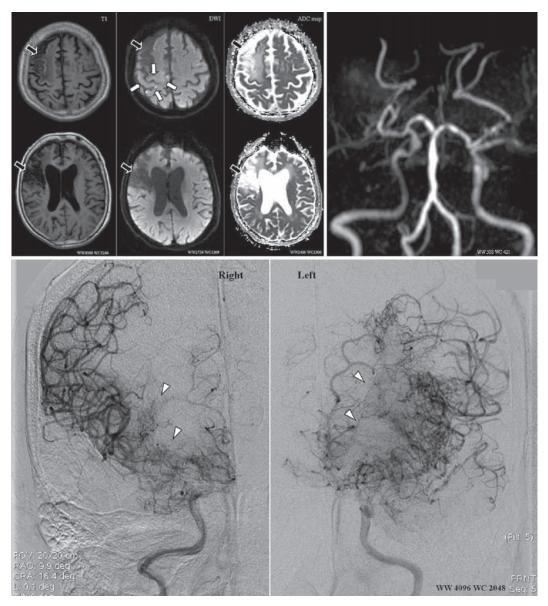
(A): Magnetic resonance imaging, including T1, diffusion weighted imaging (DWI) and apparent diffusion coefficient map (ADCmap). (B): Symptomatic time-of-flight angiogram. (C): Digital subtraction angiogram of the bilateral internal carotid arteries.
